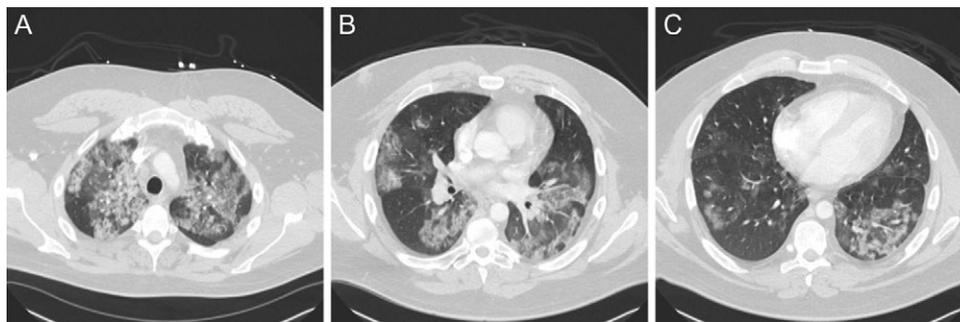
Contrast-enhanced chest computed tomography on hospital Day 1 displaying (A) the apices of the lungs, (B) the mid-lung zones and (C) the lung bases demonstrating upper-lobe predominant diffuse ground-glass opacities and centrilobular nodules.
